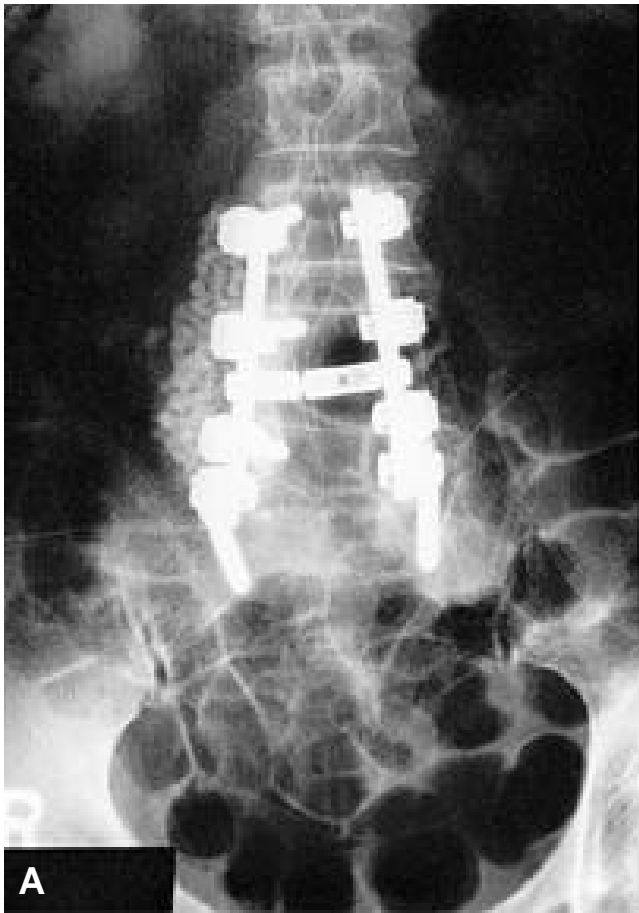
Postoperative roentgenogram
